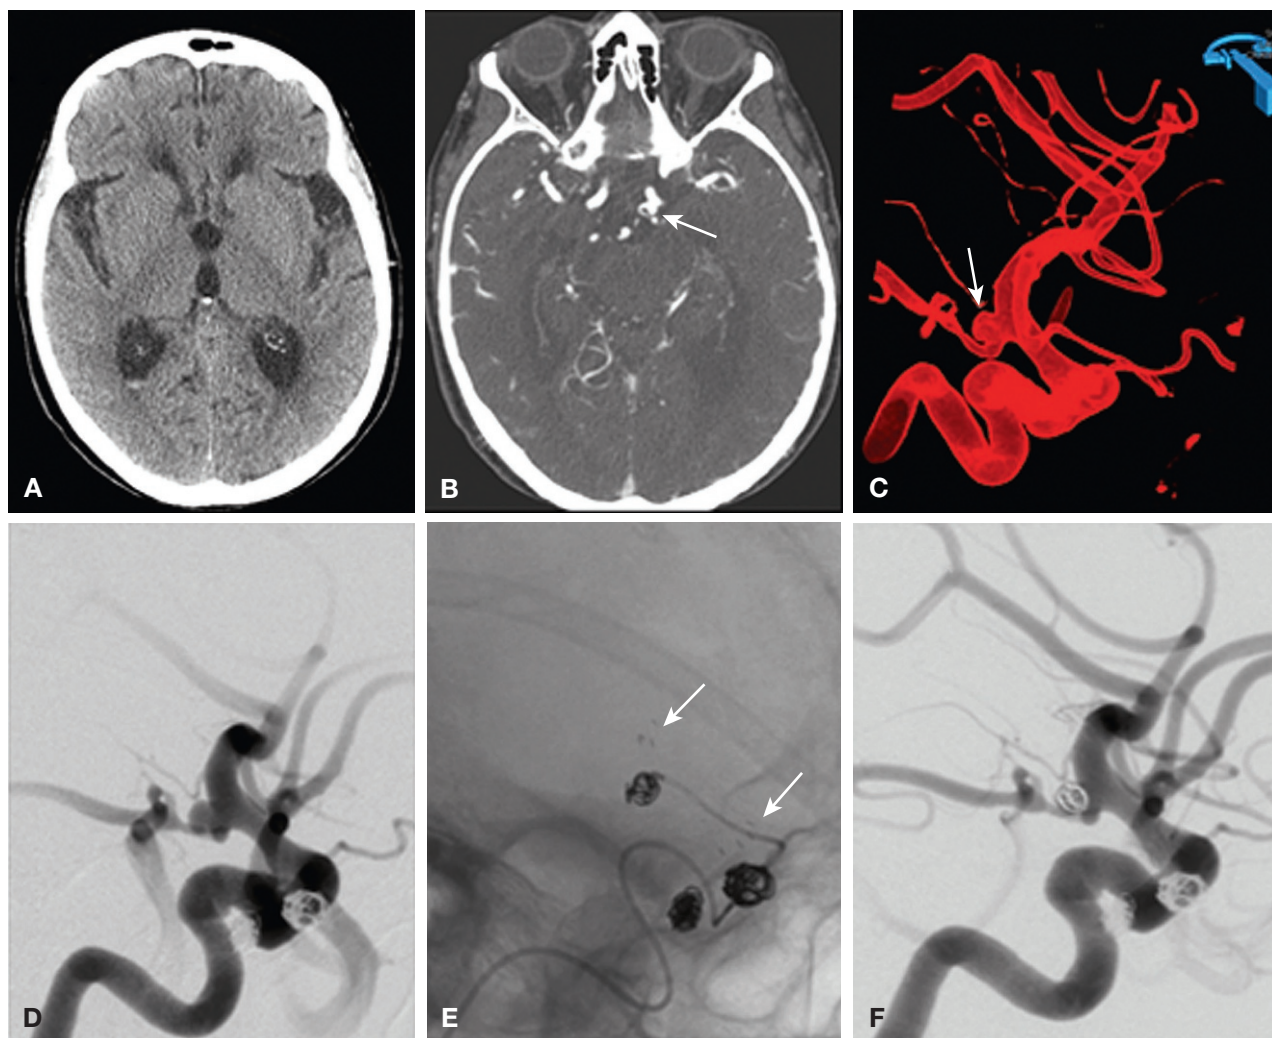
The patient is an elderly woman with a recent small subarachnoid hemorrhage. CT scans without (A) and with (B) contrast agent demonstrate blood layering in the occipital horn of the right lateral ventricle and a small, wide-necked aneurysm at the origin of the left posterior communicating (PComm) artery (arrow). C, Three-dimensional reconstruction of a rotational angiogram shows the aneurysm at the PComm origin (arrow). D, E, and F, Lateral views of a left internal carotid angiogram show successful treatment of the PComm aneurysm using stent-supported coiling. (Note that two contralateral internal carotid aneurysms had already been treated with endovascular coiling.) In E, the ends of the stent (arrows) are radiopaque.
